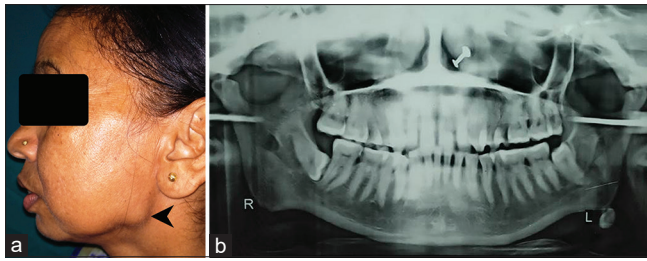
(a) Extraoral swelling at left mandibular posterior region. (b) Orthopantomogram showing one radiopaque mass at the left angle of the mandible
